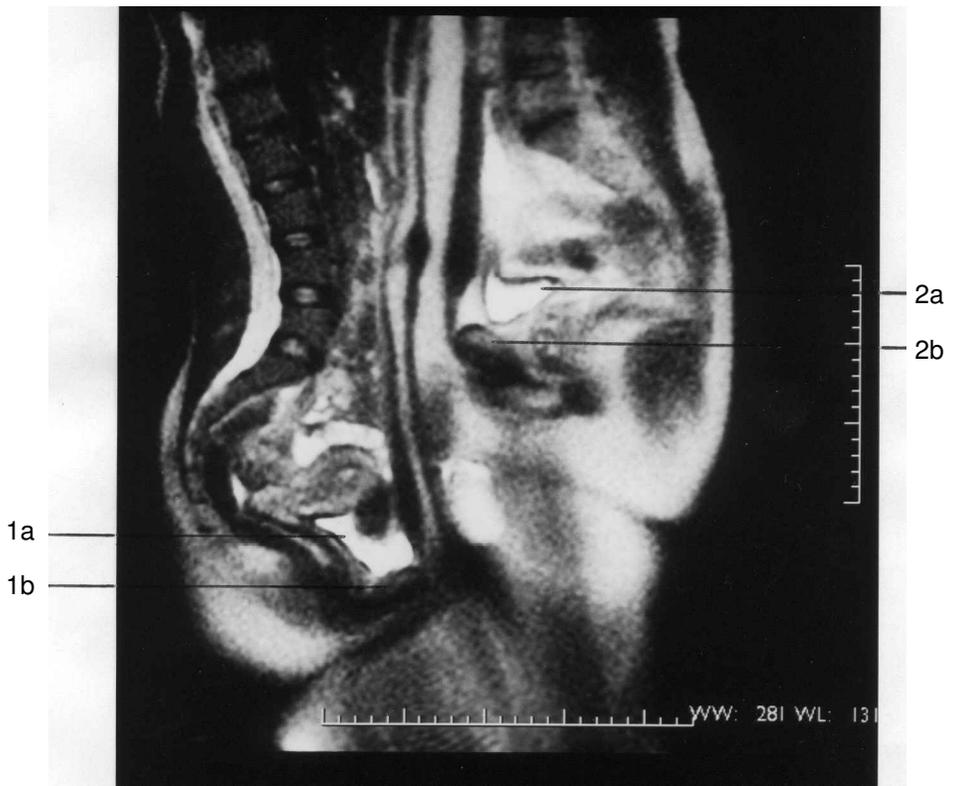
MRI photograph of first session, showing female bladder (1a) and pubis (1b), and male bladder (2a) and pubis (2b).
